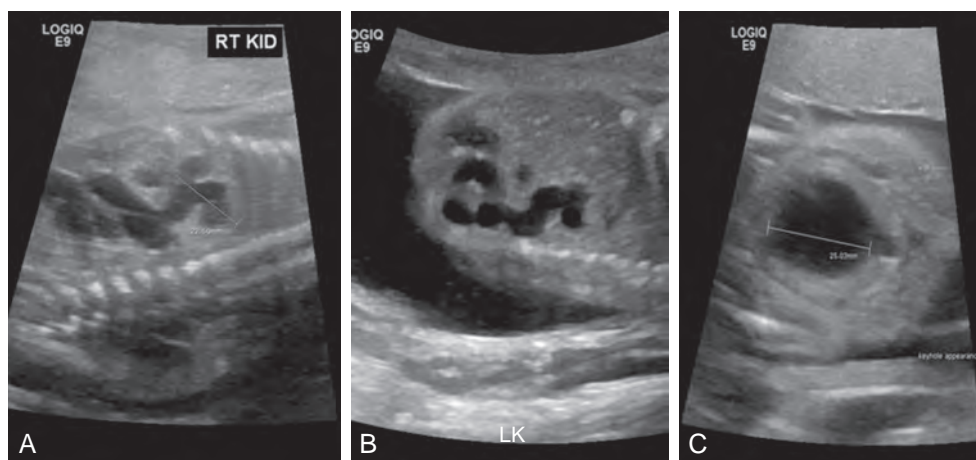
Prenatal sonogram demonstrating bilateral (A and B) hydronephrosis and hydro-ureter and the thickened bladder and “keyhole” sign (C) typically associated with bladder outlet obstruction, in this case of posterior urethral valve.
